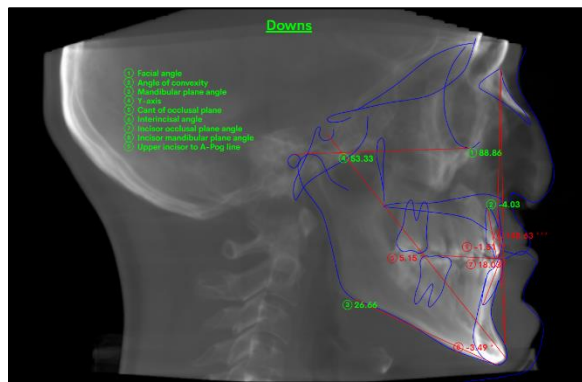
CBCT assisted lateral Cephalogram showing cephalometric analysis using WebCeph
